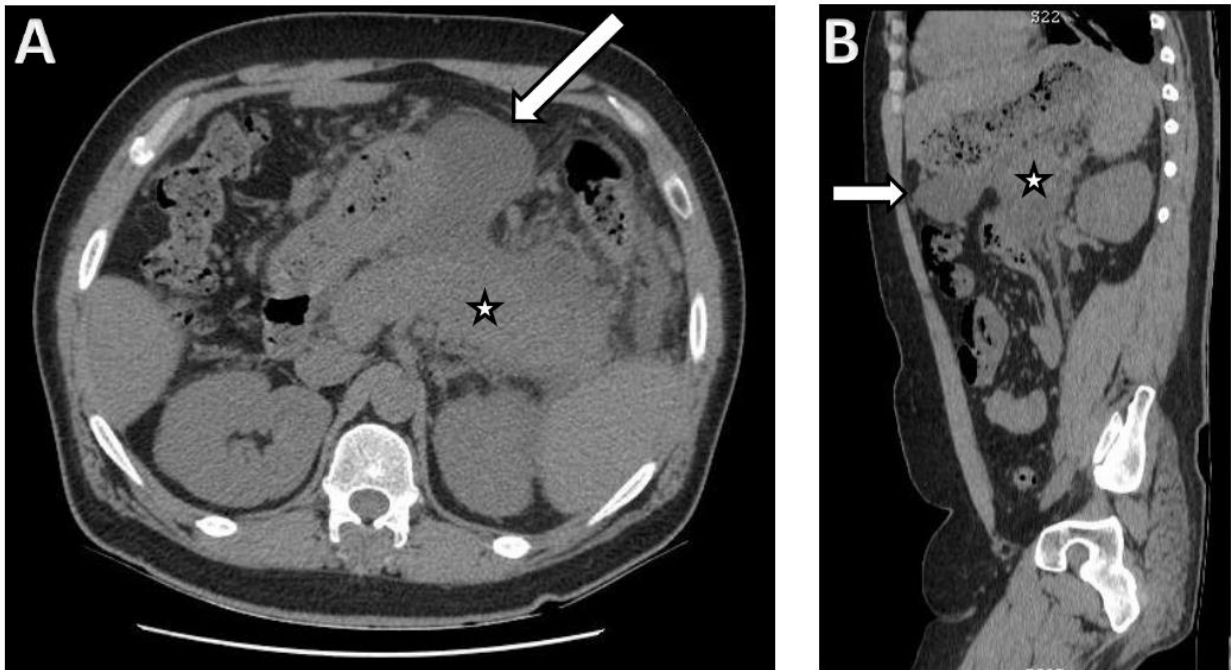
Figure 1. Axial (A) and sagittal (B) planes of CT scan of the patient's abdomen on his initial assessment showing an enlarged pancreas (Star) with indistinct margins and reduced density (due to oedema) with surrounding fat stranding and thickened Gerota's fascia. Note the large pancreatic pseudocyst which is a non-capsulated homogenous peripancreatic fluid collection (solid arrow).
